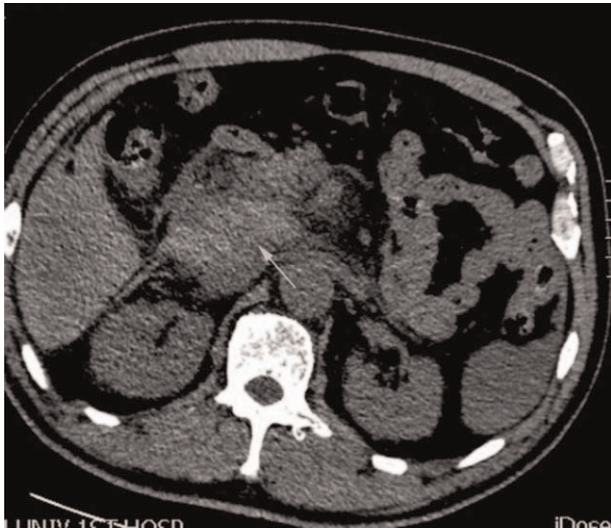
Abdominal CT done at 18h later showed hyperattenuation with CT value of 50 to 60 Hu at pancreatic head. CT = computed tomography.
